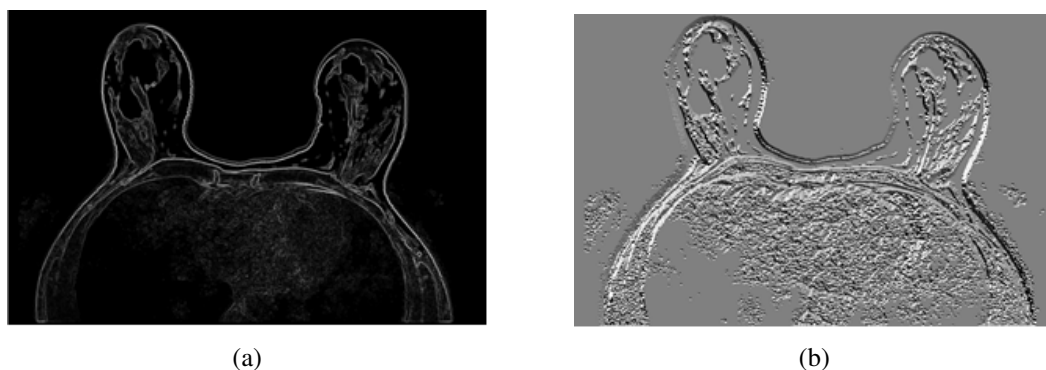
Magnitude (a) and phase (b) representations of chest MRI in axial cut.
